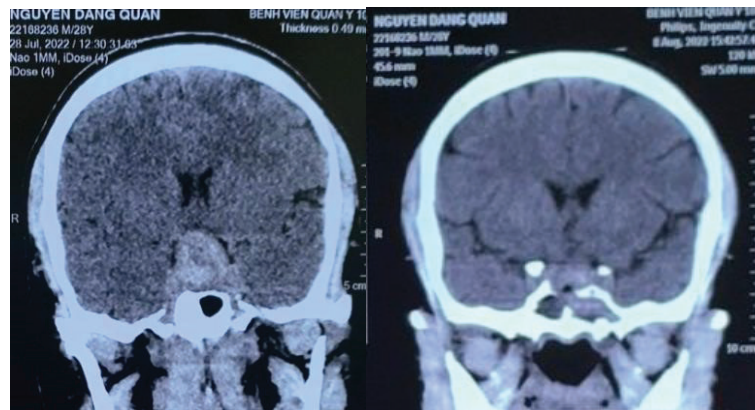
Coronal CT scan: Images before and after surgery show a smaller pituitary mass. The mass effect on the optic and cavernous sinuses is no longer evident.
